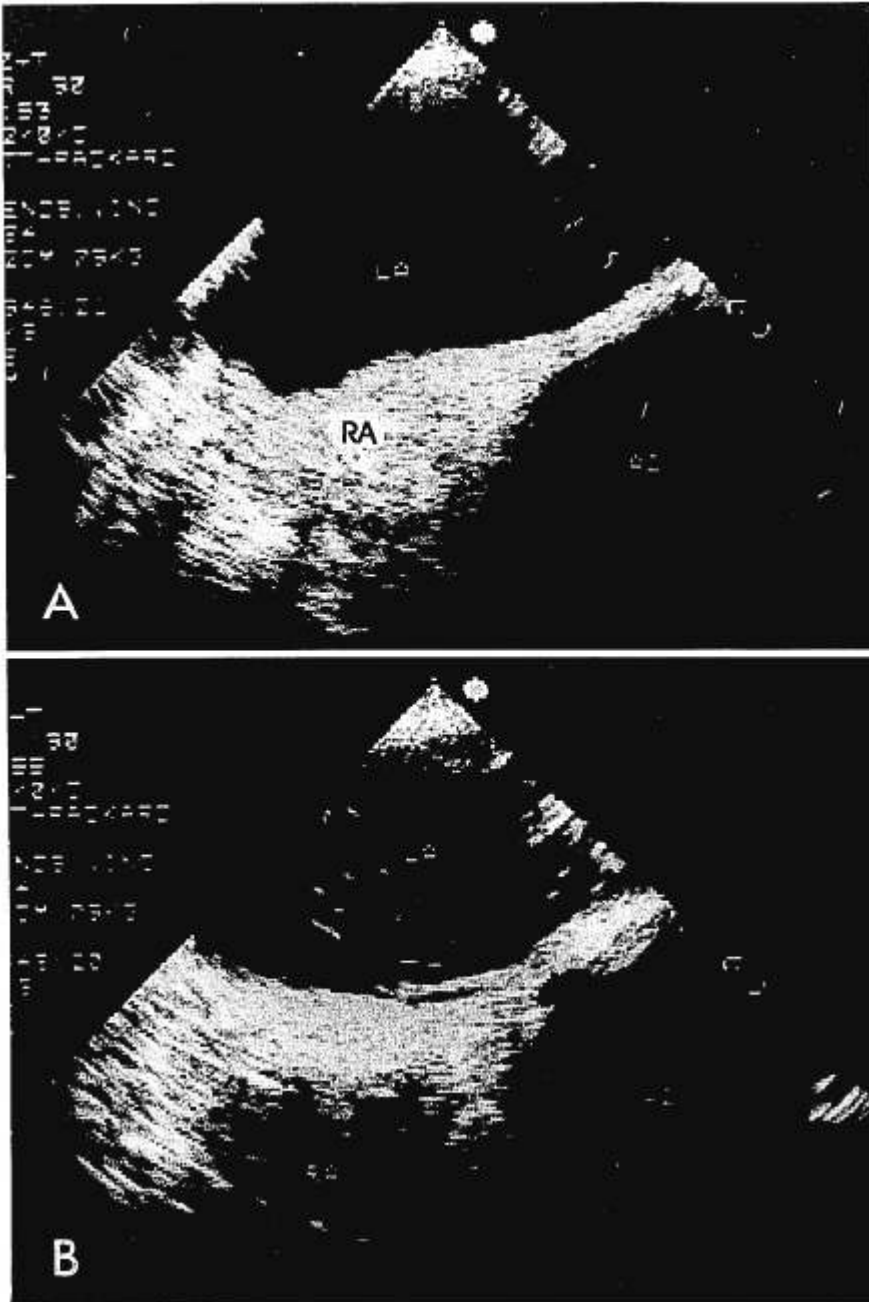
(A) Biatrial echocardiographic view during contrast injection. Note complete opacification of the right atrium. (B) Same view as (A) after airway pressure release. Note the appearance of echo contrast in the left atrium. RA = right atrium; LA = left atrium; AO = aorta.
